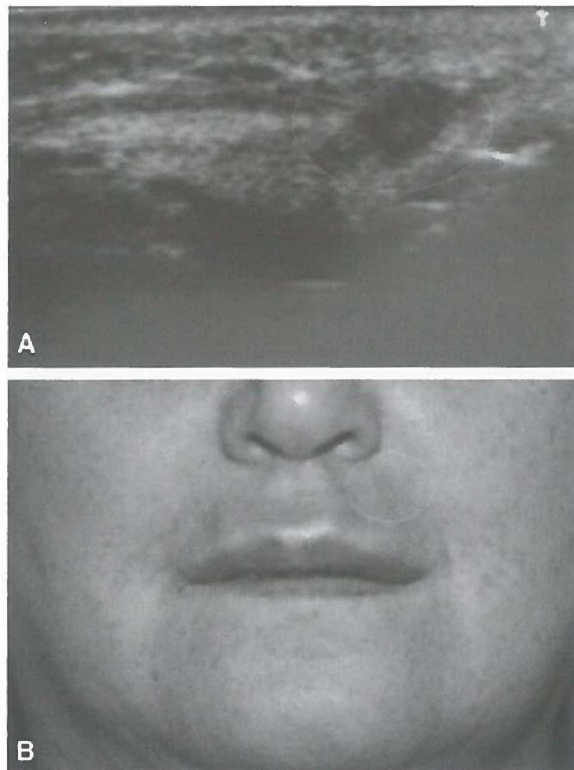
A, Granuloma of left nasolabial fold, 2 years after Bio-Alcamid injection. White circle indicates an area of irregular sonographic pattern without a distinct edge from healthy tissues. B, white circle indicates the corresponding area of the sonographic image. A hard lump was palpated in left nasolabial fold.
